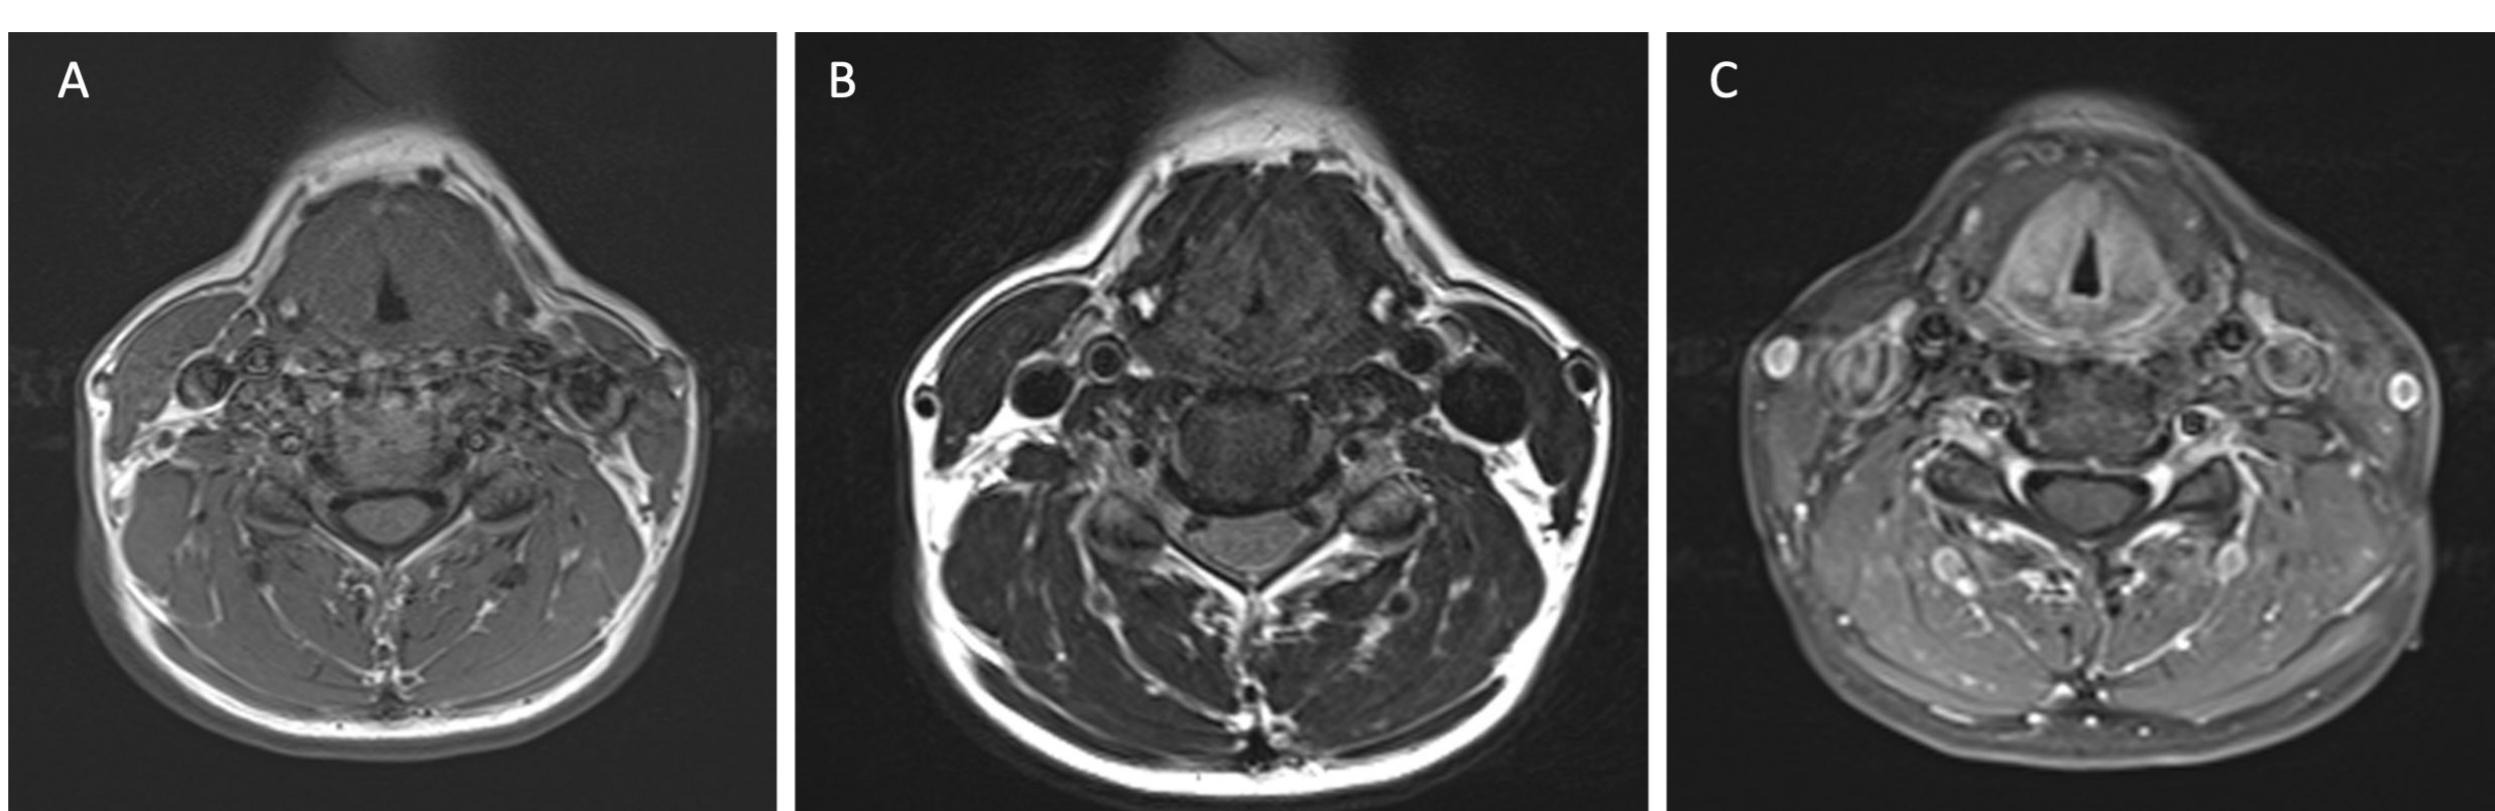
Supraglottic lesion demonstrates typical signal characteristics of amyloidosis with moderate T1-weighted hypointensity (A), marked T2-weighted hypointensity (B), and mild to moderate diffuse contrast enhancement on T1-weighted fat suppressed MR images (C).
